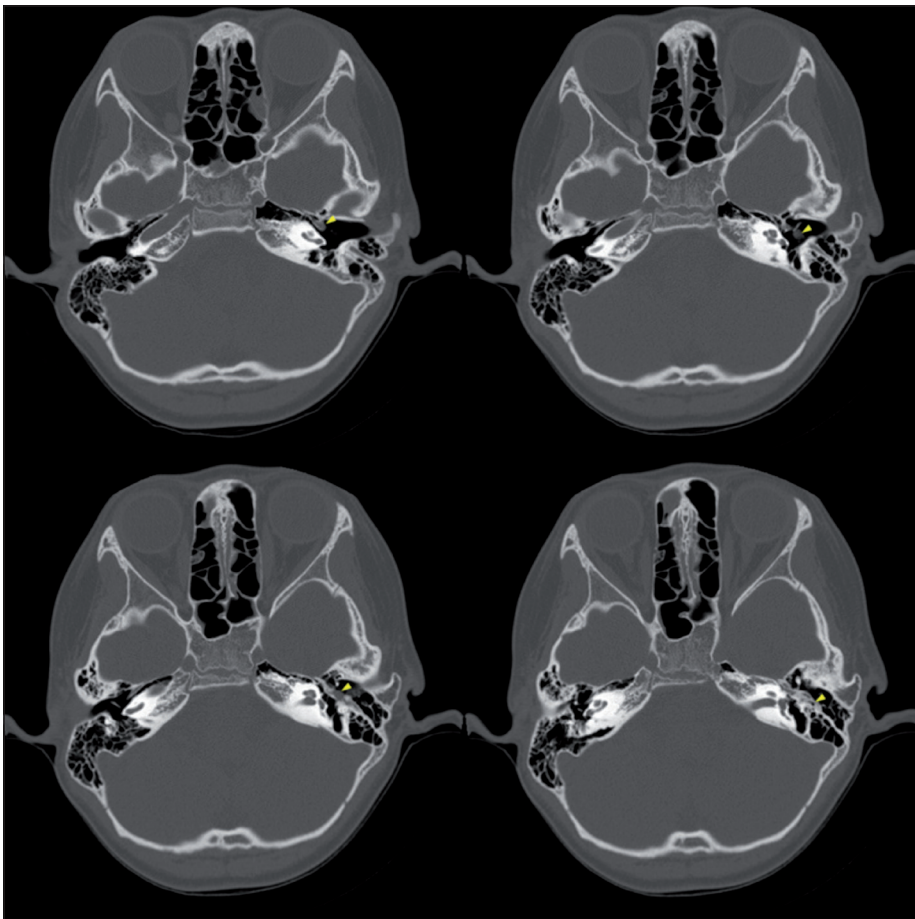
Computed tomography scan of the temporal bone demonstrated diffuse thickening of the tympanic segment of the left facial nerve with focal herniation into the middle ear cavity (yellow arrowheads) just posterior to the long limb of incus.
